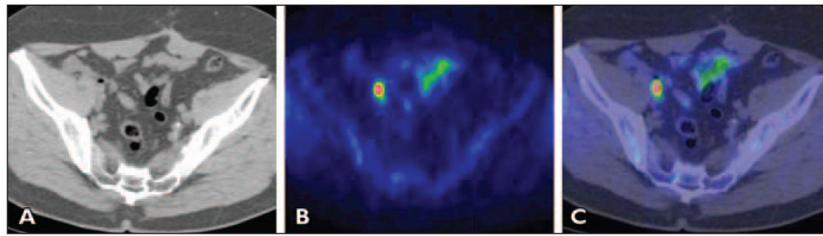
Man with biochemical relapse of prostate cancer (prostate-specific antigen [PSA] level, 2.68 ng/mL). A–C, CT (A), PET (B), and fused PET/CT (C) images show pathologically increased ¹¹C-choline uptake in subcentimeter right external iliac lymph node. Pelvic lymph nodal area was irradiated with resultant decline in PSA to undetectable level at 3 months after completion of therapy regimen. (Reprinted with permission from [218])
